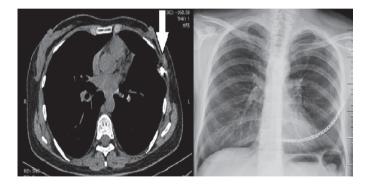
Preoperative view of the mass in the left fifth rib and postoperative chest X-ray showing titanium bridge
